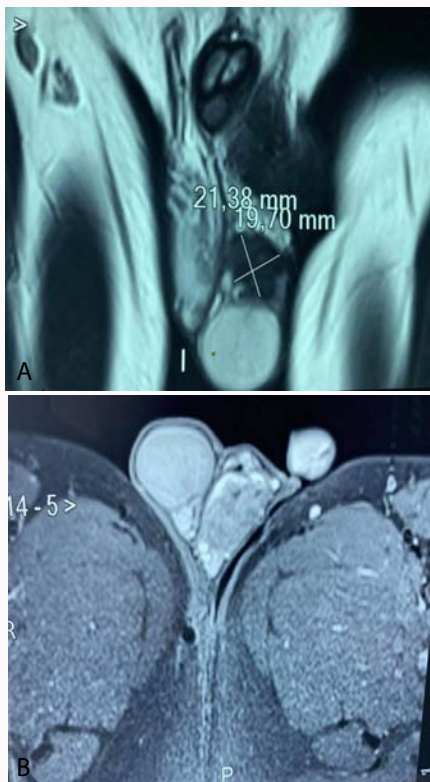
A: Testicular MRI, coronal slice, T2 showing the epididymal mass. B: Testicular MRI, axial slice, T1.
